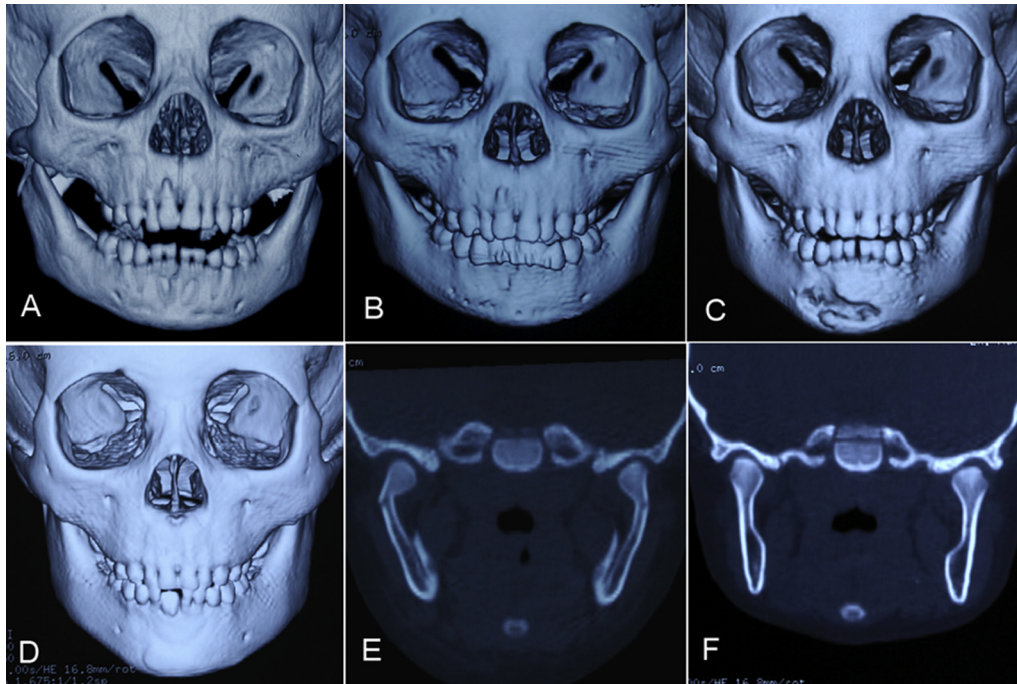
A 2-year-old boy sustained symphysis and bilateral condylar fractures from a high fall. (A) Preoperative 3-dimensional CT of the fractures. (B) A 3-dimensional CT scan 1 week after the operation showing good reduction of the symphysis fracture and screw hole images on both sides of the fracture line at the lower margin. (C) A 3-dimensional CT scan 6 months after the operation revealing severe osteolysis at the biodegradable fixation site. (D) A 3-dimensional CT scan 2.5 years after the operation showing good reossification at the osteolytic region. (E) Preoperative coronal CT of the bilateral condylar neck fractures. (F) Coronal CT at 2.5 years later showing good remodeling of the bilateral condylar processes.
